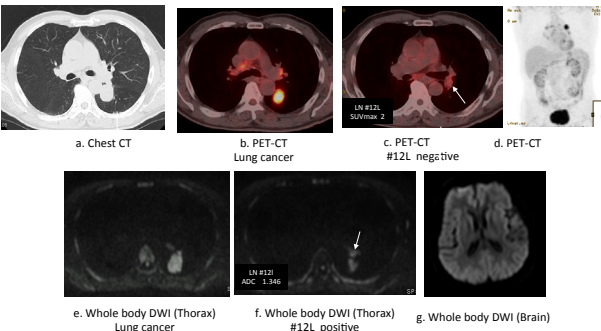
64 y.o. male with small cell carcinoma. The lung cancer was diagnosed as cT2aN0M0 (cStage IB) disease by PET-CT and brain MRI, but cT2aN1M0(cStage IIA) disease by whole body DWI. Whole body DWI showed lymph node station #12L as positive (f), but not negative by PET-CT. The lung cancer was diagnosed as pT2aN1M0(pStage IIA) disease pathologically.
